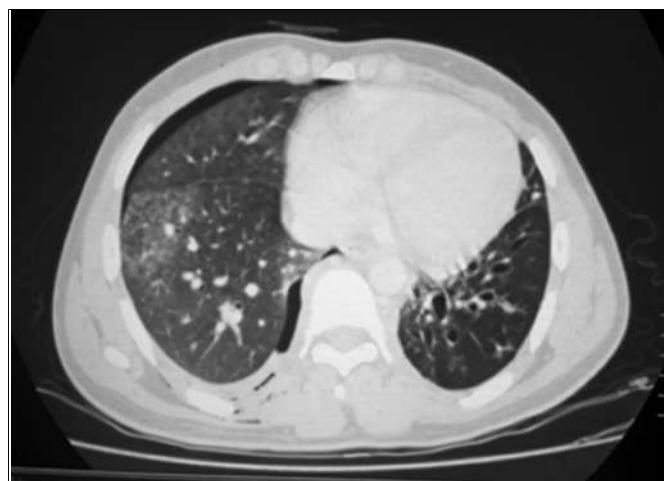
CT scan of patient showing right sided occult pneumothorax.
